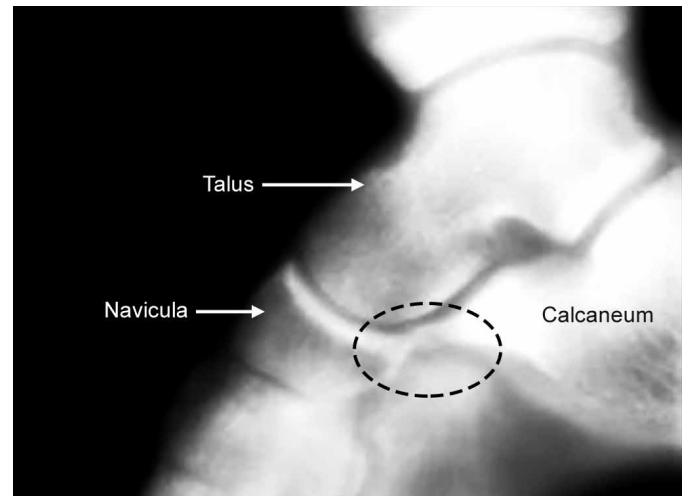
X-ray of tarsal coalition between calcaneum and navicular.
